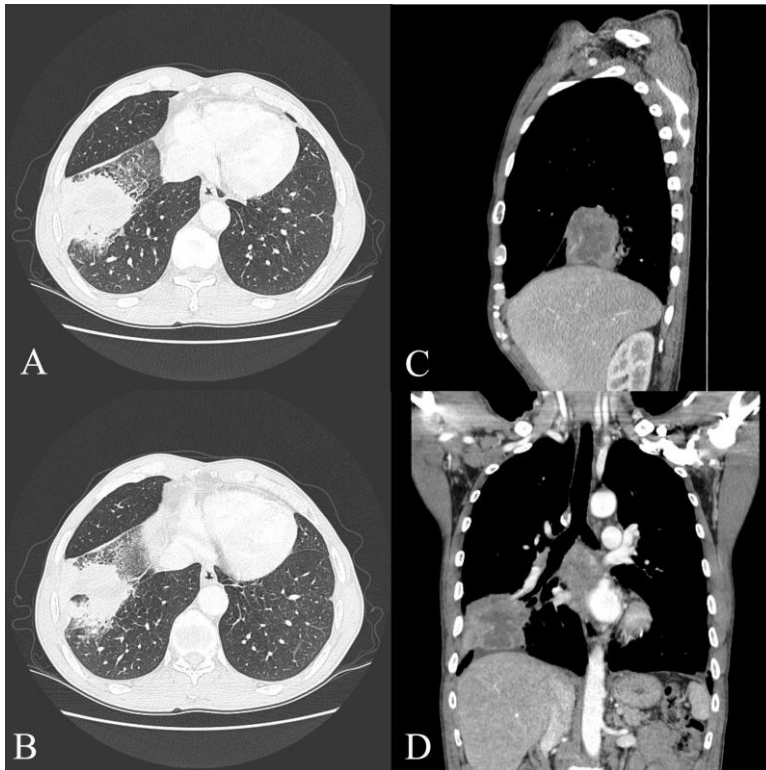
CT scan showed a 7.2 cm sized heterogeneously enhancing mass with necrosis in RLL anterobasal segment. A, B: axial images of lung, C: coronal image of lung, D: sagittal image of lung.
